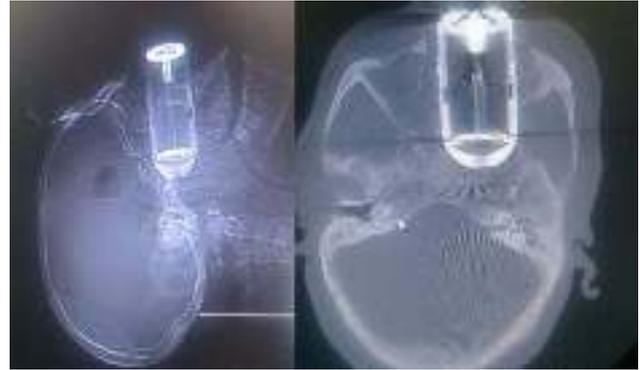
CT views of Patient-2
